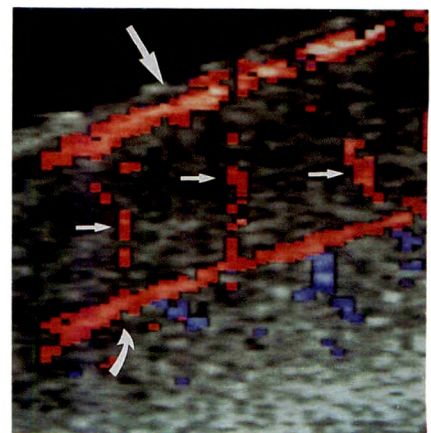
Color flow sonogram of corpora cavernosa shows dorsal artery (long straight arrow), cavernosal artery (curved arrow), and helicine branches (small arrows).
